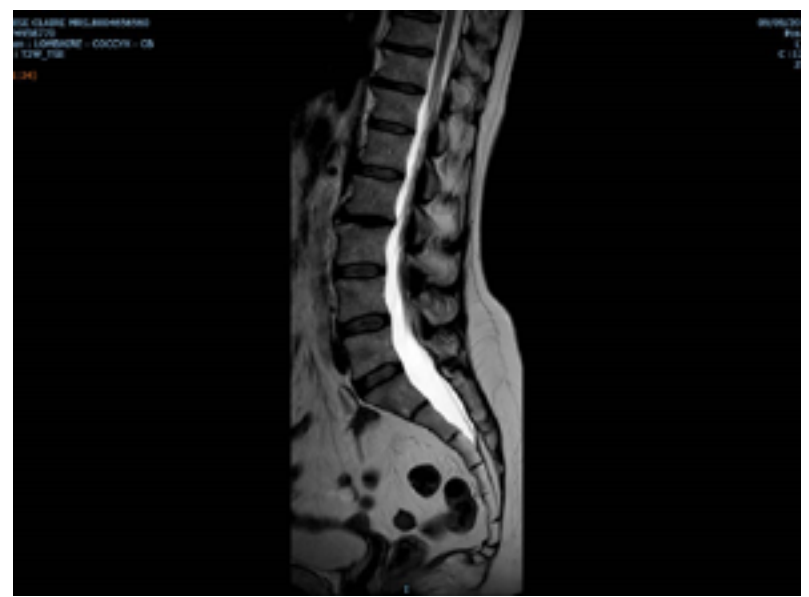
MRI including the sacrum and the coccyx. The distal chordoma is located at the button limits of the field of this MRI, but visible in this case
